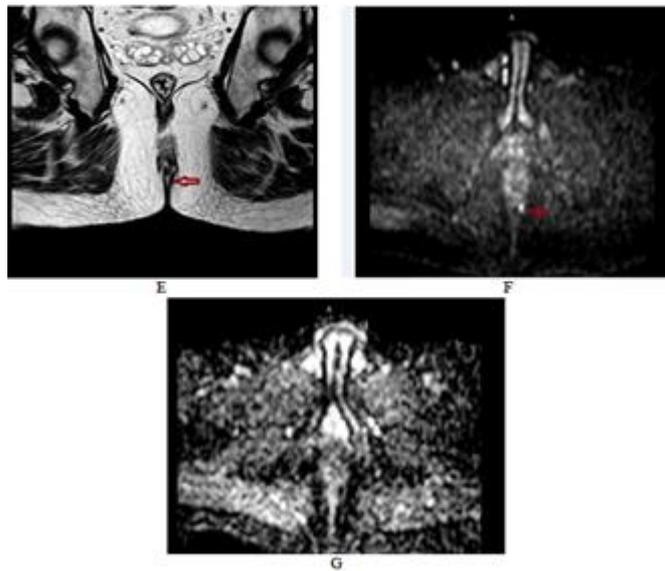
grade 1 intersphincteric fistula that showed (A-E) well visualization of fistulous tract on axial T2, STIR and coronal T2 images (red arrow) that showed high signal intensity on T2WI and STIR (score 2). (F, G) Restricted diffusion of fistulous tract on DWI (red arrow), score 2 (well visualized) and ADC value = $1.31 \times 10^{-3} \text{ mm}^2/\text{s}$.
